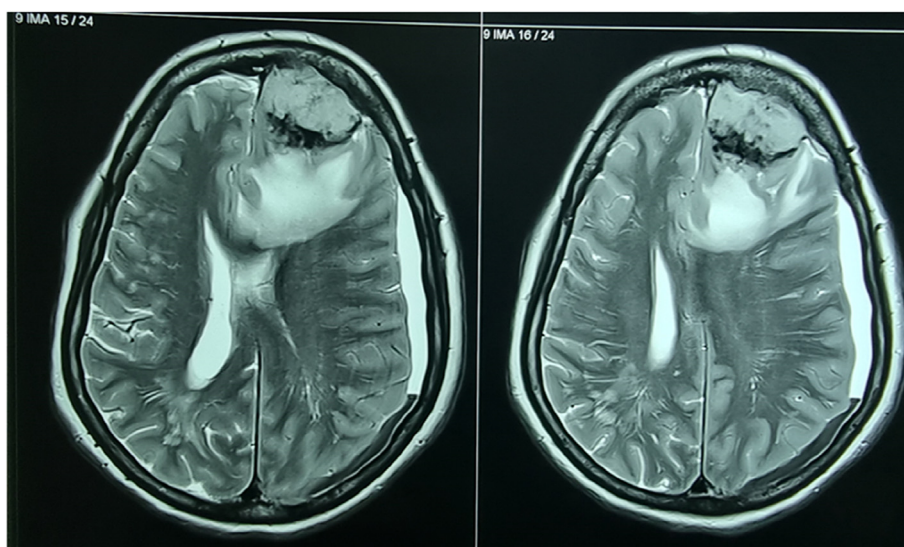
jpg: T2 axial MRI brain showing left frontal hyperintense lesion with surrounding perilesional edema with left frontotemporal subdural hyperintense lesion suggestive of chronic hematoma.
